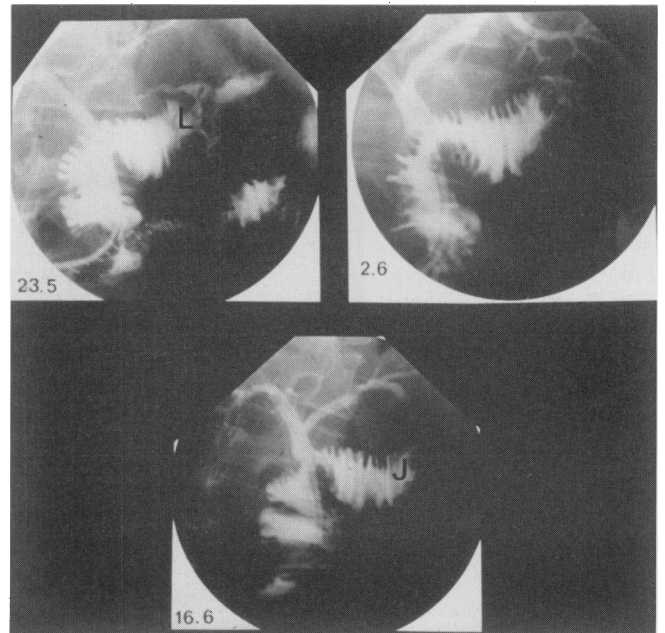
X-ray with contrast medium injected through tube splinting the hepaticojejunostomy. L = leak of contrast medium through the pancreaticojejunostomy; J = the anastomosis has healed 24 days later.
